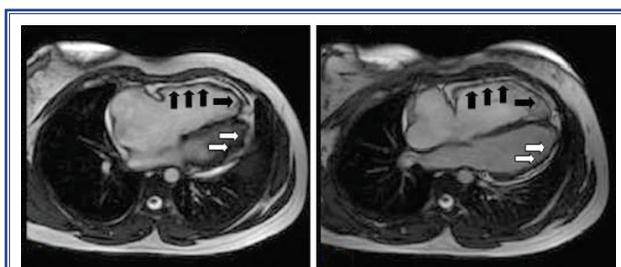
Fiestra (Fast Imaging Employing Steady State Acquisition) sequence cardiovascular magnetic resonance images from the sisters with ARVC indicate fat infiltration at the outflow tract, free wall, and apex of the right ventricle and thinning of the underlying myocardial wall (black arrows) and a thinned lateral wall of the left ventricle (white arrows) due to fatty replacement.
